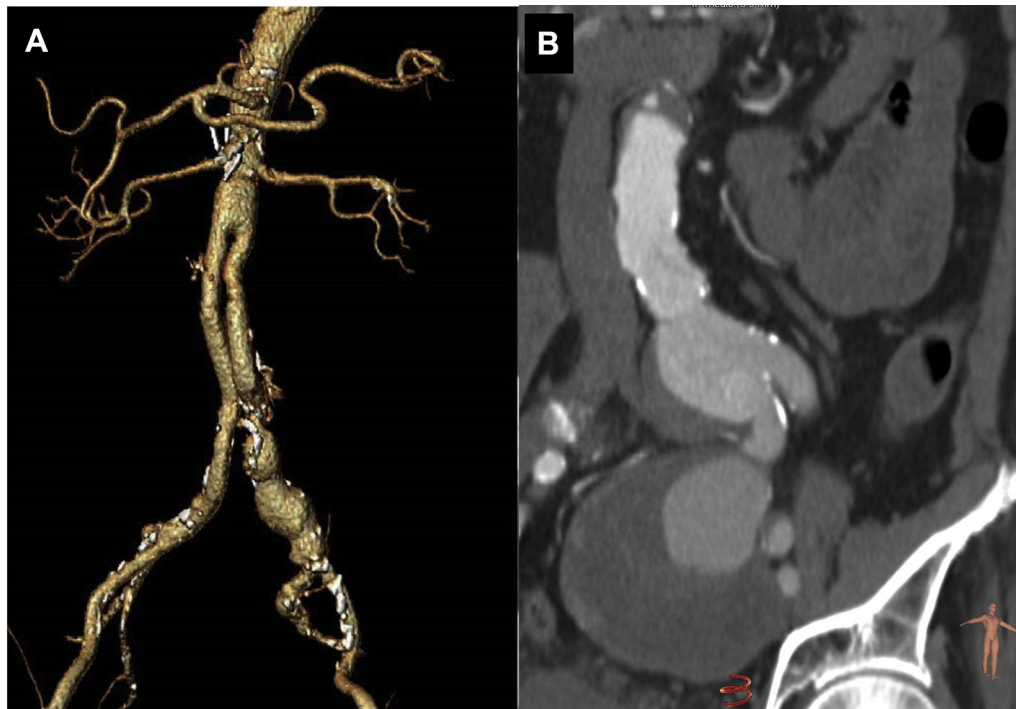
Preoperative CTA imaging. (A) Three-dimensional reconstruction of isolated para-anastomotic aneurysm involving left common iliac artery and its
